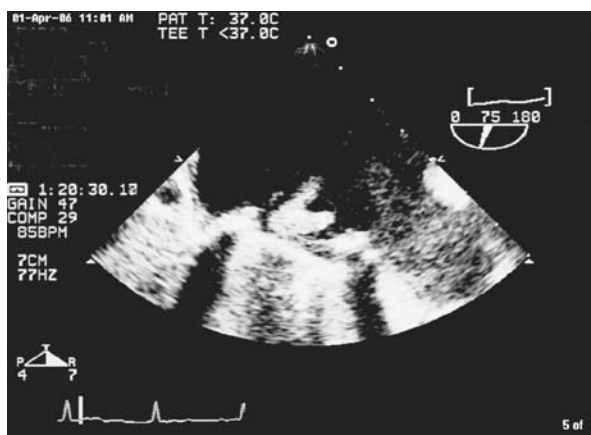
Transesophageal echocardiography demonstrated a recurrence of a large vegetation on the MV prosthesis (16 days postoperative follow up).
